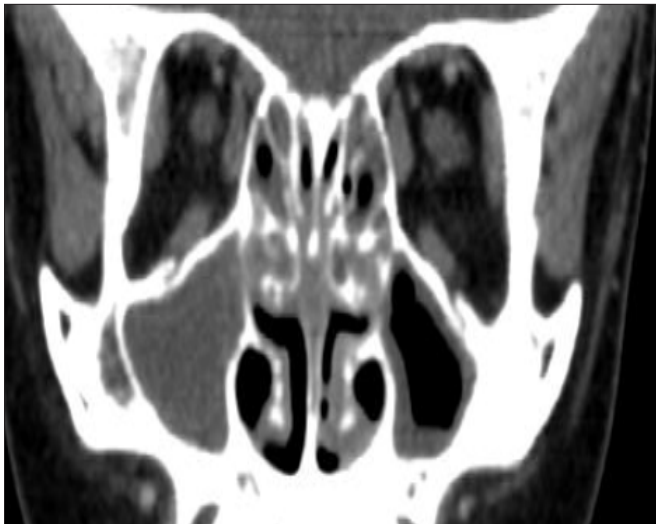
Coronal reformatted image CT of the Paranasal Sinuses (post contrast) showing extensive ethmoid and maxillary sinusitis.
